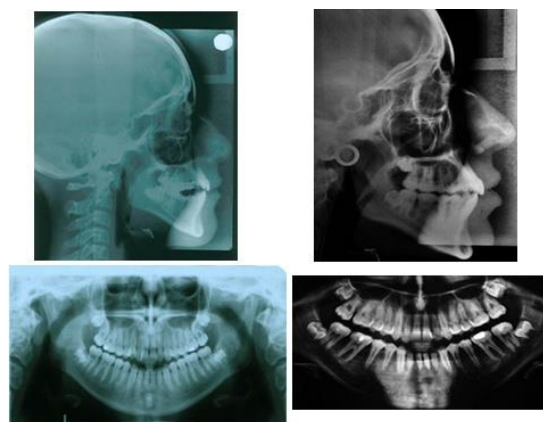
Pre and Post-treatment radiographs of case 2(N-E)
